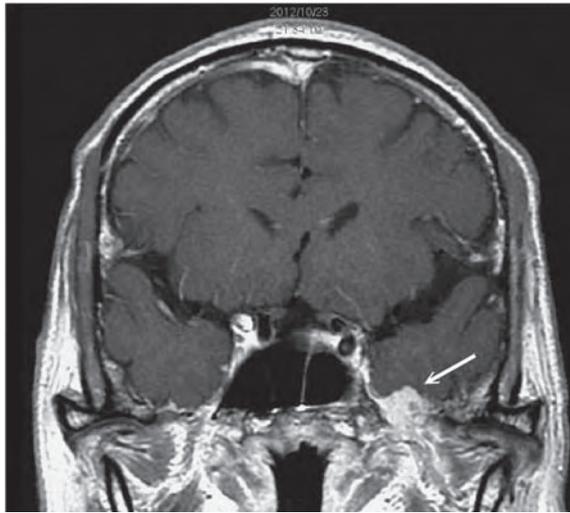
Coronal contrast-enhanced T1-weighted brain MRI. An enhanced mass (arrow) extended through the left foramen ovale.
